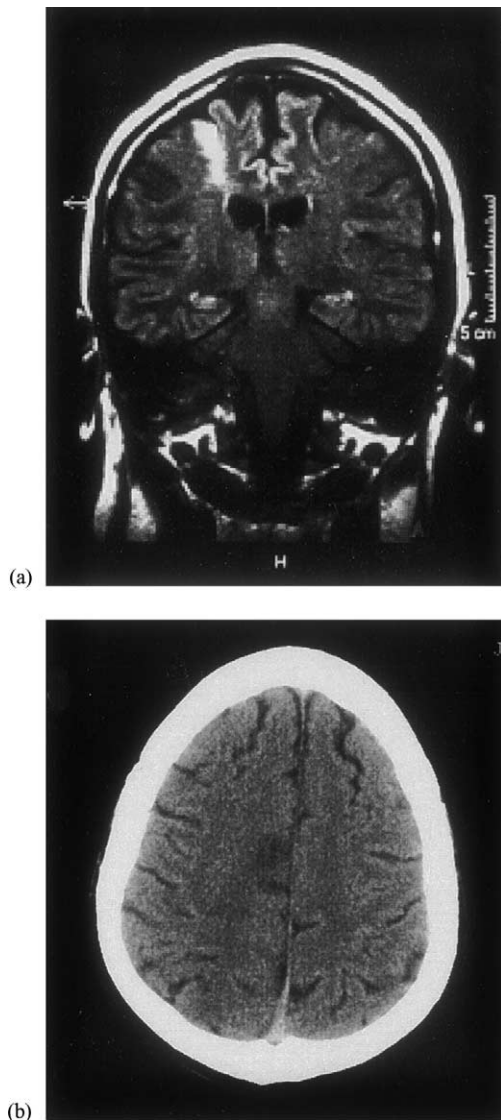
MRI scans of patients with small focal lesions affecting the frontal cortex. (a) In patient no. 2, the fronto-central lesion involved a small portion of the motor, pre-motor and adjacent pre-frontal areas in the right hemisphere. (b) In patient no. 8, the right superior fronto-central areas were affected.
